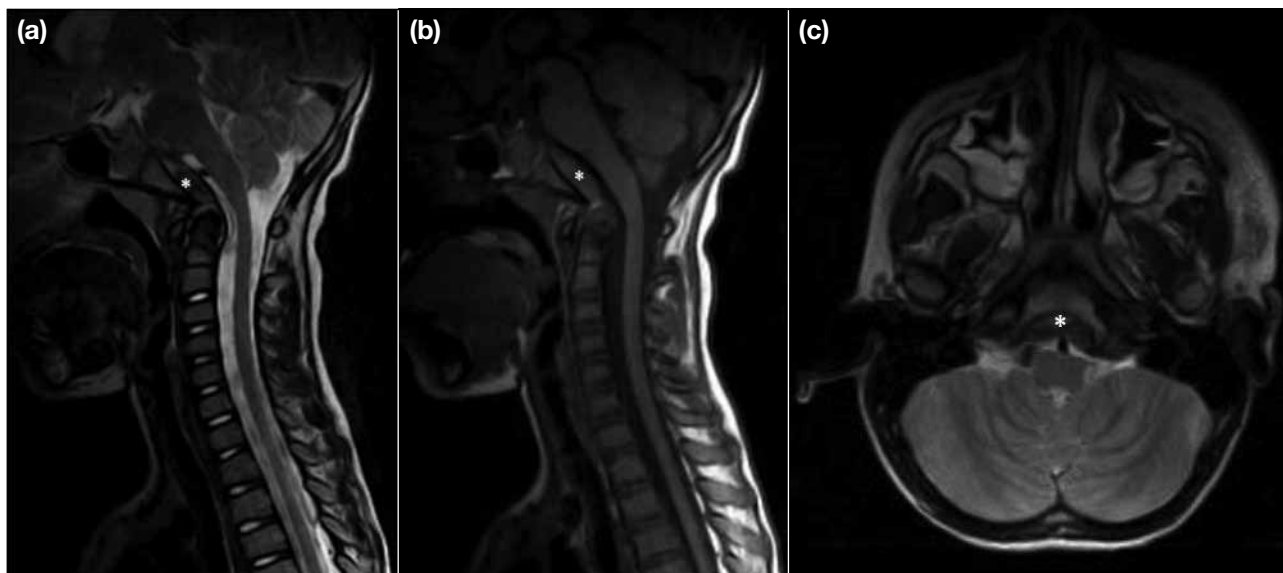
(a) Sagittal T2, (b) sagittal T1, and (c) axial T2 magnetic resonance images showing the retroclival epidural haematoma (*) anterior to the brain stem and posterior to the clivus obliterating the prepontine cistern, and measuring 9 mm in thickness.
